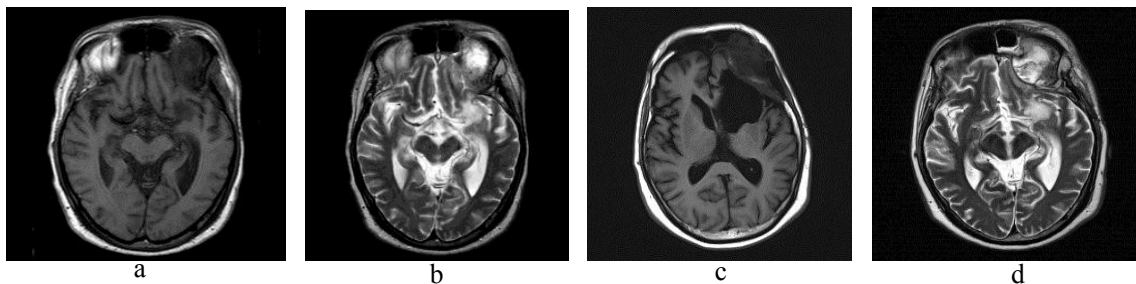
MRI scan showing axial images of a left frontal mass protruding through the left orbital fossa in (a) T1 and (b) T2 MR weighted images before surgical intervention and after (c) T1 and (d) T2 progression of disease.
